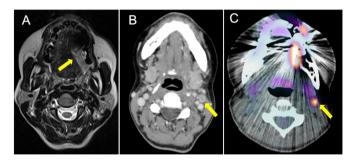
(A) Magnetic resonance imaging of a tumor mass spread to the left tongue near the center (arrow). (B) Enhanced computer tomography shows a ring-weighted mass 12x12 mm in size measured at level II on the left neck (arrow). (C) Imaging using 18-fluorodeoxyglucose-positron emission tomography/computed tomography revealed abnormal 18-fluorodeoxyglucose uptake (maximum standardized uptake values=14.7) of the left neck mass (arrow).
